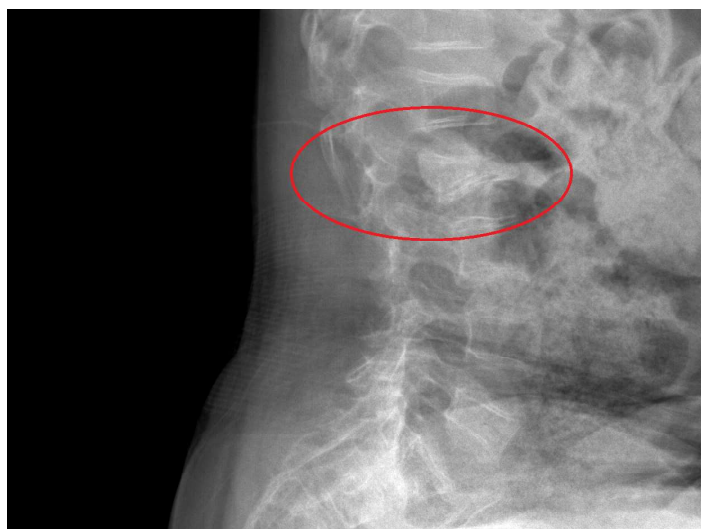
Lateral radiographic view of the spine of a patient with osteogenesis imperfecta. Note the multiple vertebral compression deformities and flattening of the vertebra ("platyspondyly"), especially at L2.
